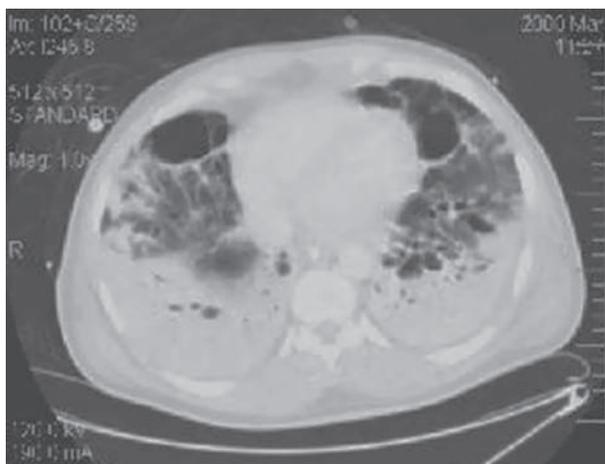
A CT scan image of a patient with ARDS showing the marked heterogeneity of the disease process (courtesy of Dr T.E. Stewart).
